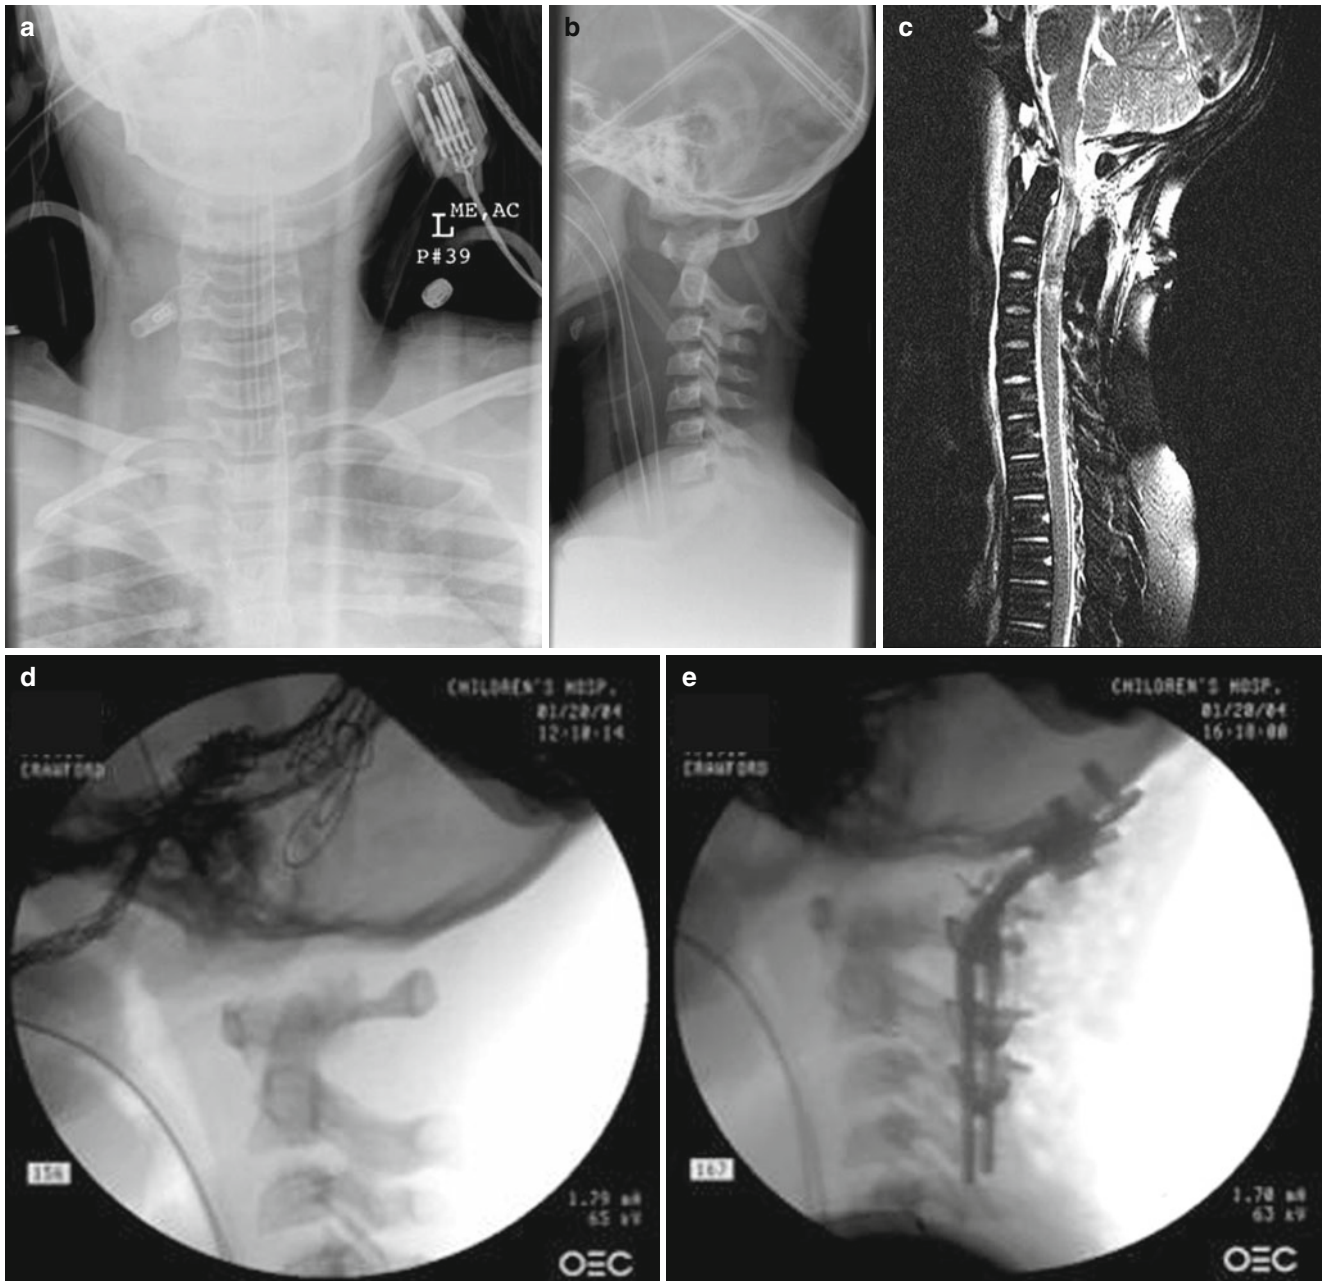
A 9-year-old female MVA victim with occipito-atlanto, axial dissociation. She was quadriplegic on admission. (a) AP cervical spine radiograph. (b) lateral cervical spine radiograph showing C1–C2 dissociation and posterior displacement of the dens. (c) T-2 weighted sagittal MRI demonstrating spinal cord transection and significant soft
